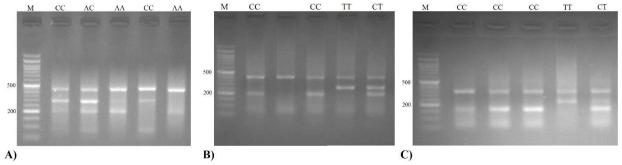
Agarose gel electrophoresis of PCR amplicons of the *VDR* gene: A) PCR products of the rs7975232 for three genotypes of AA (447 and 202 bp), CC (447 and 296 bp), and AC (447, 202, and 296 bp); B) PCR products of the rs2228570 for three genotypes of CC (409 and 197 bp), TT (409 and 267 bp), and CT (409, 197, and 267 bp); C) PCR products of the rs1544410 for three genotypes of CC (347 and 161bp), TT (347 and 230 bp), and CT (347, 161, and 230 bp). Lane M= 50 bp DNA ladder.
